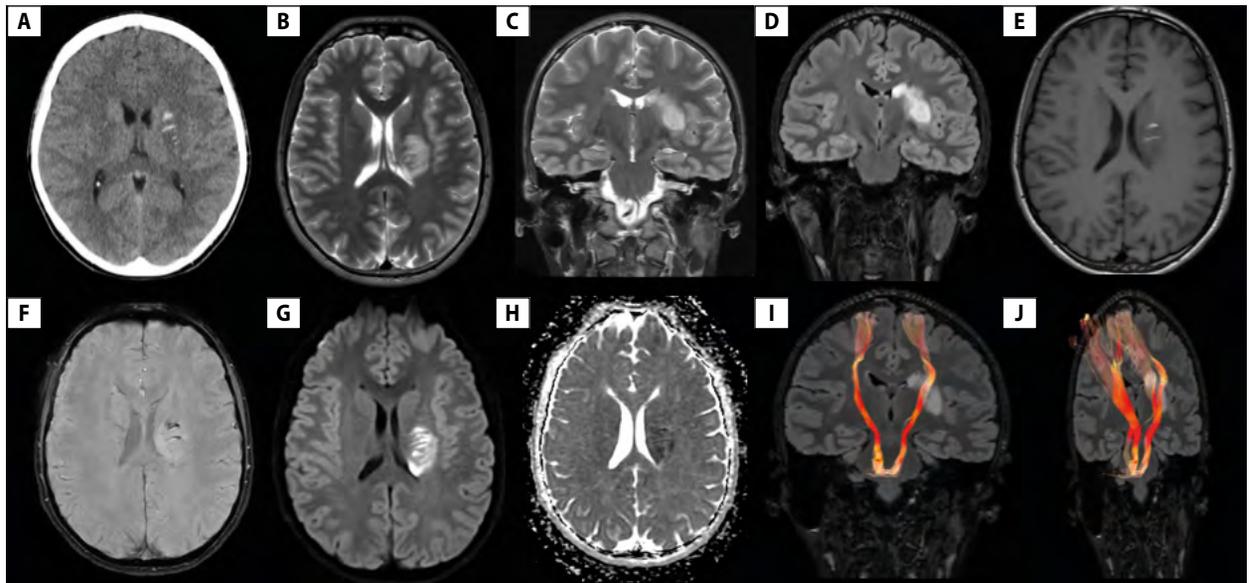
Brain image. Head CT (A) shows hypodense lesion associated with linear hyperdensities in region of left posterior corona radiata; brain MRI axial T2 (B) and coronal T2 (C) and T2 FLAIR (D) images depict a high signal intensity lesion in posterior left putamen and caudate nucleus, associated with focal linear haemorrhagic lesions hyperintense on T1 (E) and hypointense on SWI (F) corresponding to caudolenticular grey bridges and white matter interface regions; lesion shows areas of restricted diffusion evidenced by high signal on DWI (G) and low ADC (H); brain DTI tractography (I and J) demonstrates a focal loss of anisotropy in some corticospinal tract fibres crossing affected area
